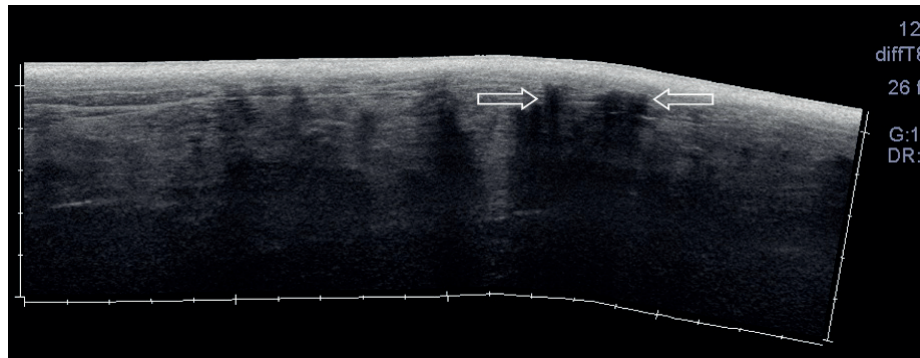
Panoramic ultrasound image of the right thigh. Multiple heavily calcified areas (arrows) are seen in the muscles.
